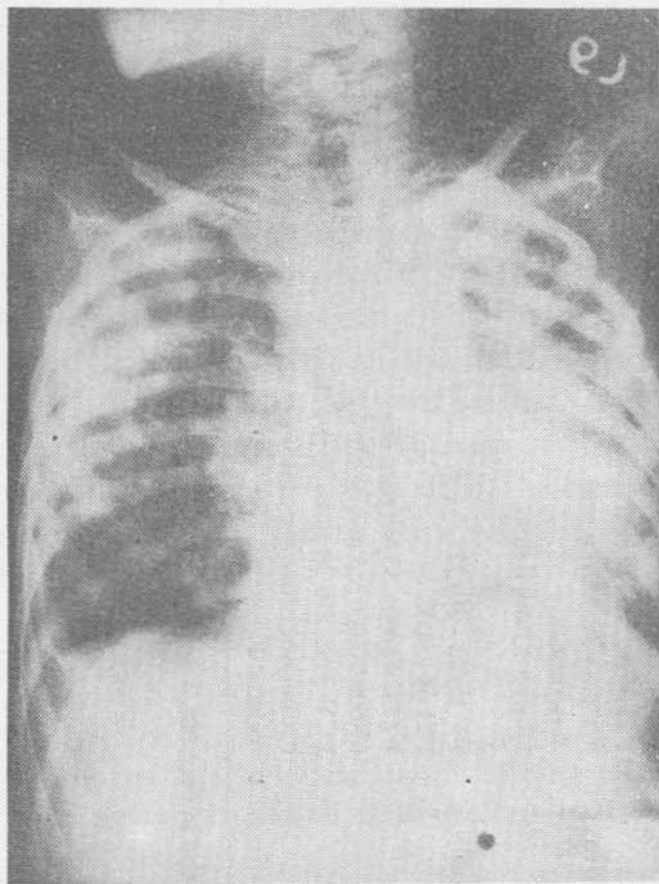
X-ray chest of patient No. 2 showing bilateral parenchymatous lesions.
